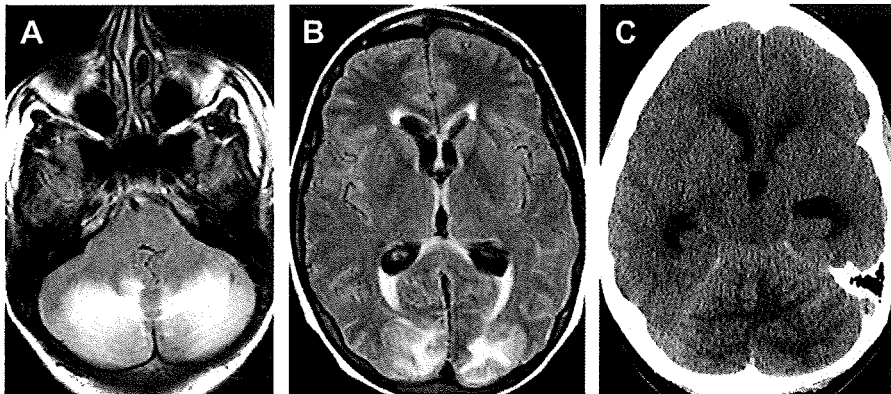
A 22-year-old woman with a history of acute lymphocytic leukemia and mental status changes. Axial FLAIR MR images (A, B) show cortical and subcortical FLAIR hyperintensity bilaterally in the occipital lobes and the superior cerebellar hemispheres. FLAIR images also show mild hydrocephalus with dilatation of the lateral ventricles and periventricular FLAIR hyperintensity consistent with transependymal flow of cerebrospinal fluid. An axial CT image (C) also shows hypoattenuation in the superior cerebellum and mild hydrocephalus with dilatation of the lateral and third ventricles. After 2 months, follow-up MR image (not shown) demonstrated resolution of the findings that were attributed to PRES.
